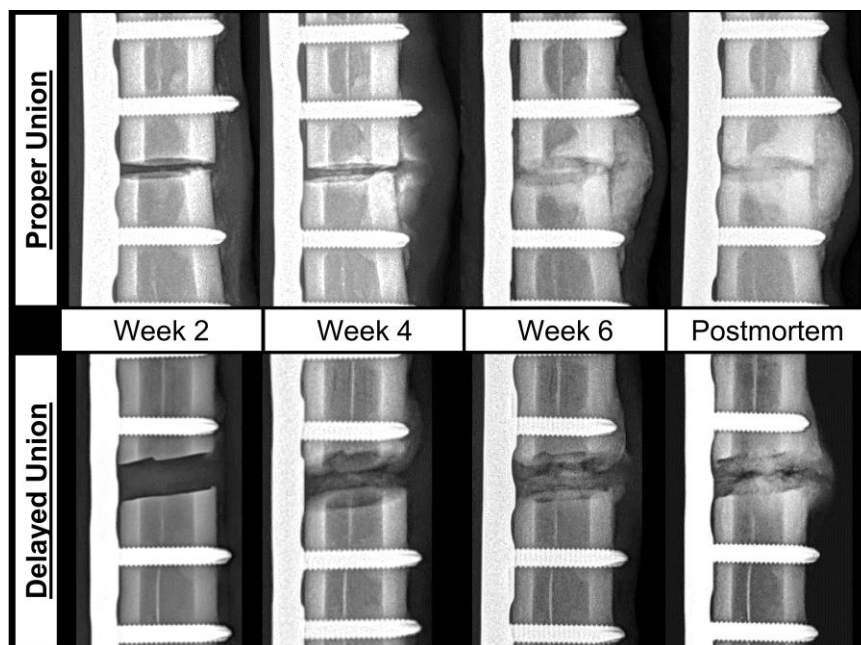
Radiographic progression of individual representative samples progressing towards proper (top row) or delayed (bottom row) fracture union.
